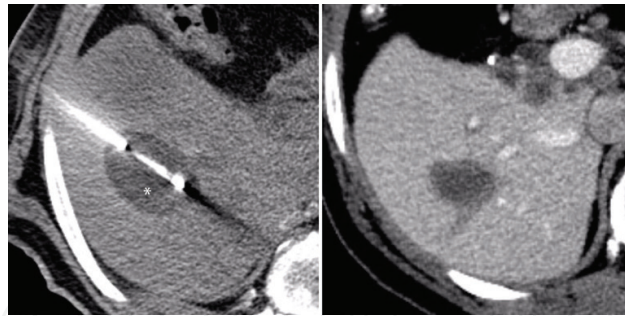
Hepatic cryoablation. A cryoablation needle was advanced into a focal hepatic lesion (left), with a resultant ice ball visible on CT (asterisk). Follow-up imaging demonstrated a focal defect at the site of the previous lesion (right), consistent with a complete ablation.
